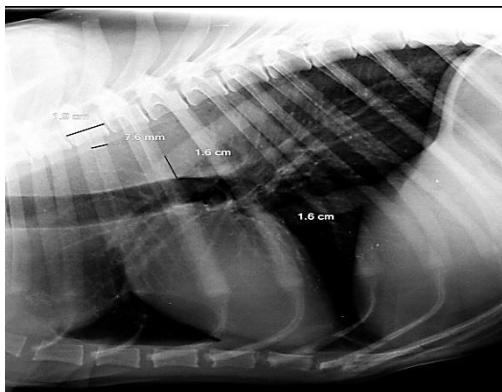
Right lateral Thoracic Radiograph showing normal pulmonary area, cardiac inclination angle along with well-defined cardiac vasculature
